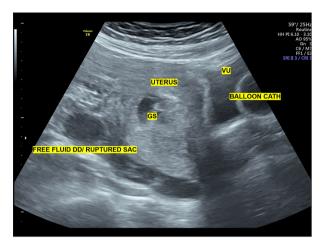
Transabdominal ultrasound showing free fluid suggestive of ruptured ectopic pregnancy and a gestational sac (GS) within the uterus, indicative of a heterotopic pregnancy. Additional annotations include the uterus, balloon catheter (for bladder visualization), and urinary bladder (VU).
